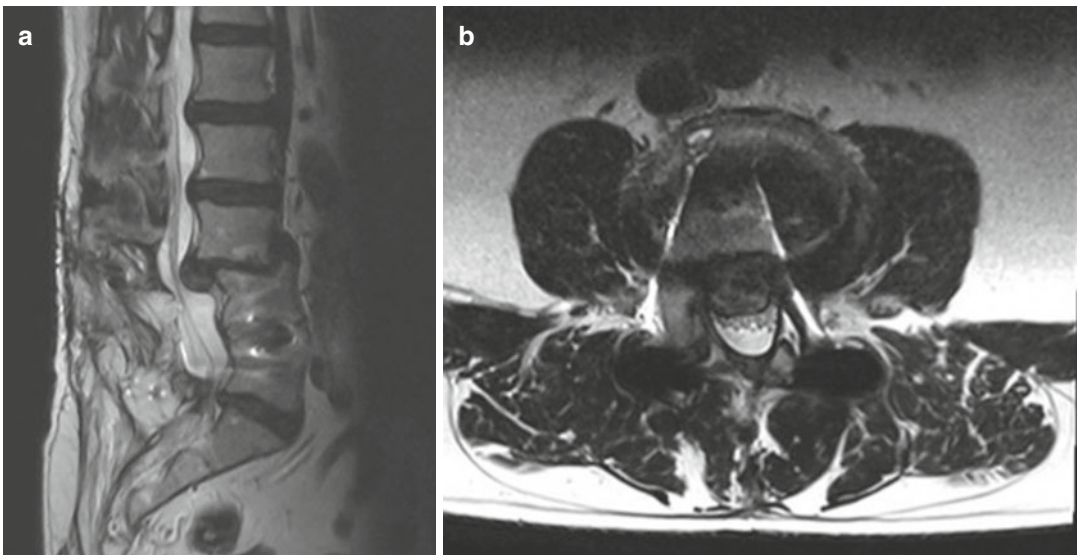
The MRI of the lumbar spine is showing a huge recurrent disk herniation (a) and a severe segmental instability (b) at the level L3/4
